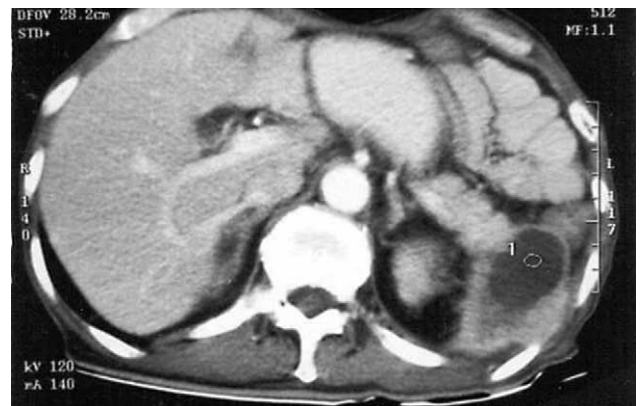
CT scan showing the metastatic lesion in the spleen.
